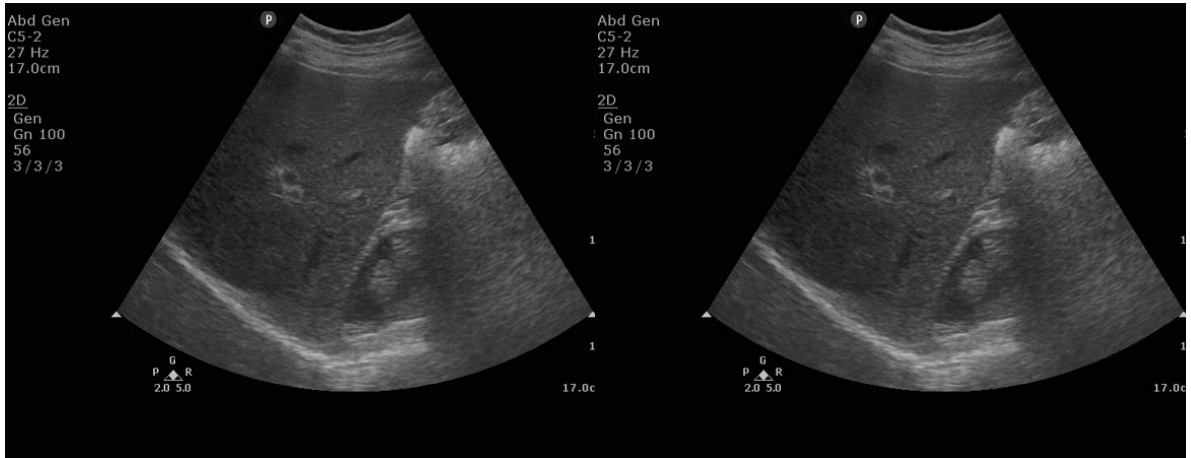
A - Real Ultrasound Machine
